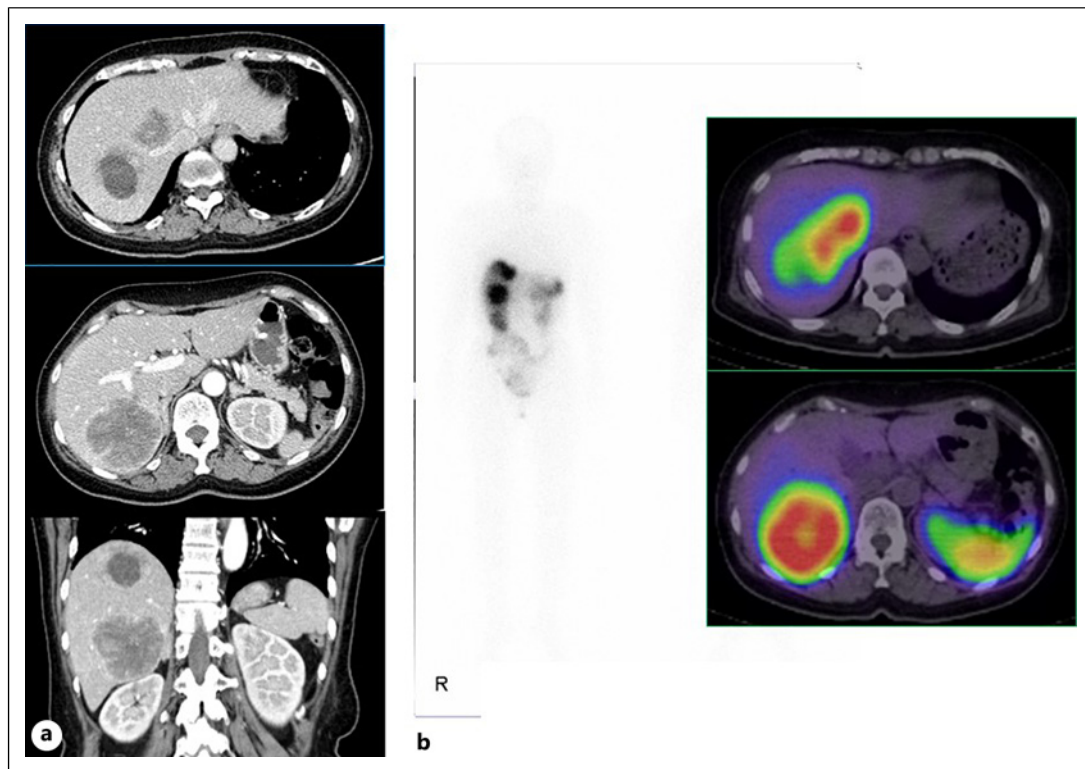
Radiographic findings on diagnosis. a Abdominal enhanced computed tomography detected hepatic masses with almost identical patterns of heterogeneous enhancement at the time of admission. b These hepatic lesions were positive on somatostatin receptor scintigraphy using ^{111}In -labeled pentetreotide.
